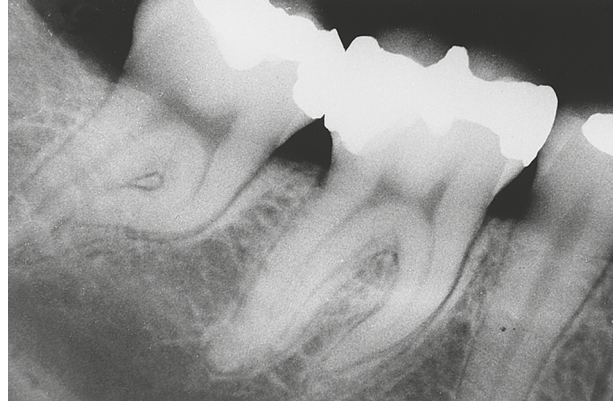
Dilaceration of an extracted permanent mandibular first molar and permanent mandibular second molar on a radiograph, respectively. (From Ibsen OAC, Phelan JA: *Oral pathology for dental hygienists*, ed 6, St Louis, 2014, Saunders/Elsevier.)
